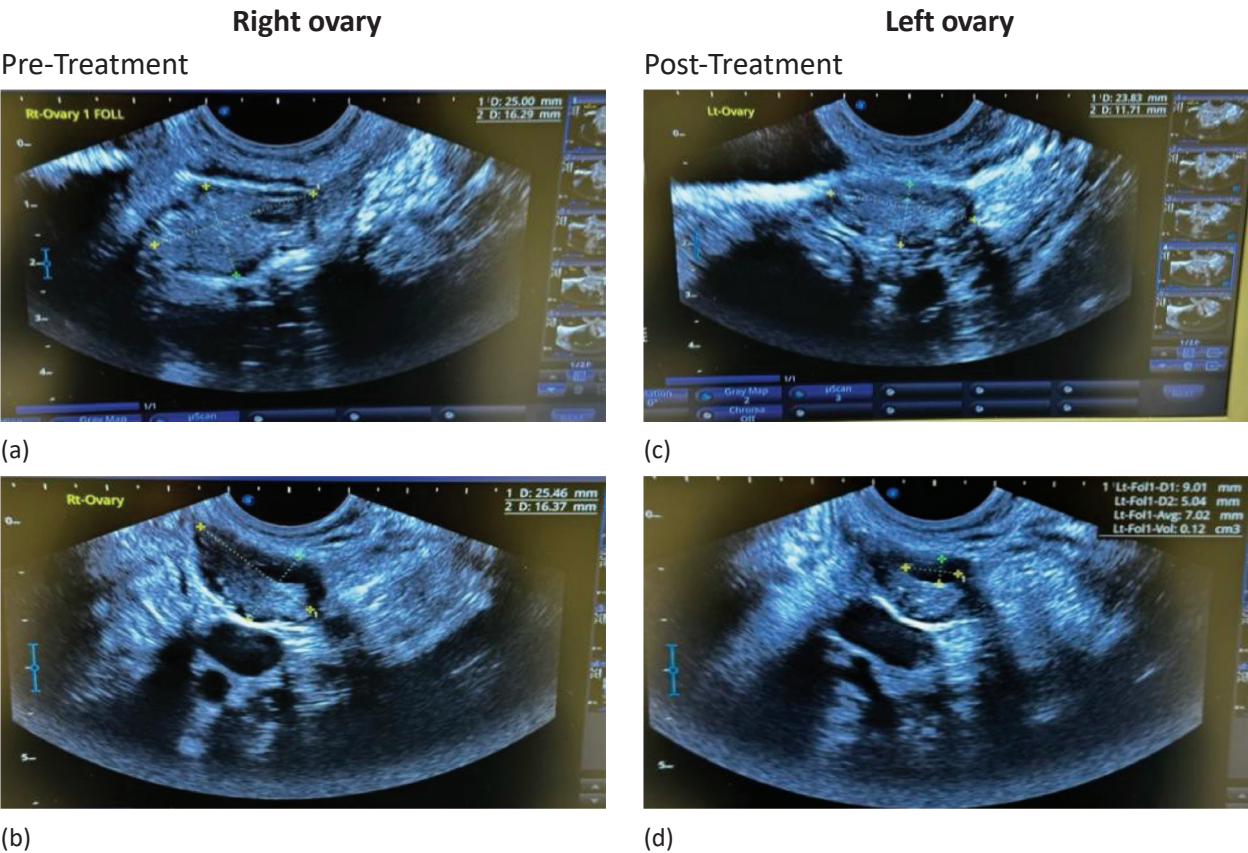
Transvaginal ultrasound monitoring of bilateral ovarian architecture pre- and post-autologous ADSC transplantation. (a) Baseline pre-treatment scan of the right ovary showing reduced follicular activity with a single small, restricted antral follicle. (b) Post-treatment evaluation of the right ovary showing persistence of the follicle with increased follicular size.
